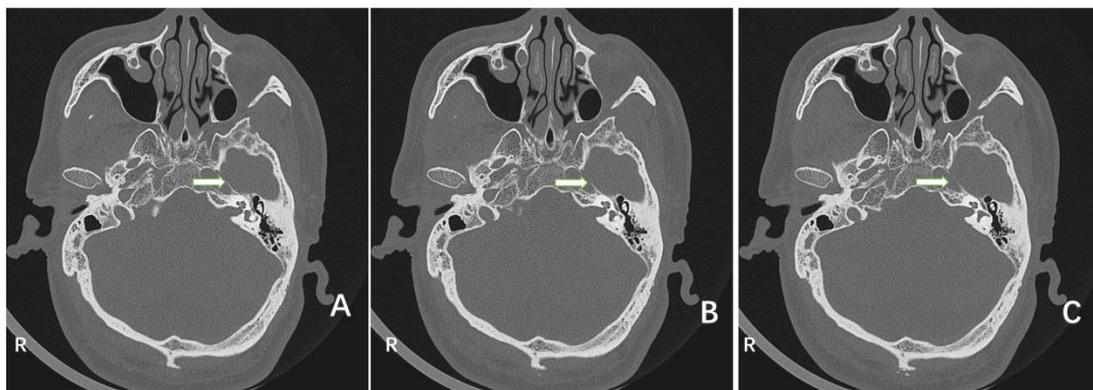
A, B, C: Mastoid CT taken before MRI. The left internal auditory canal is lightly widened(arrows) compared with the normal meatus on the right.
